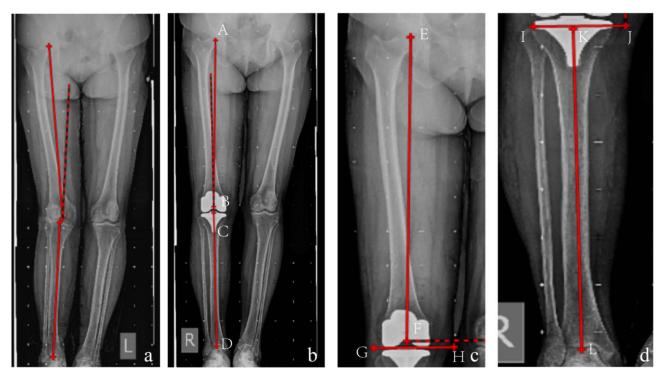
Postoperative measurement of component and limb alignment for RATKA. (a) Preoperative radiographs of limb alignment of patients. (b) Postoperative HKA angle: the angle between line AB and line CD. (c) Postoperative LDFA Angle: the angle between line EF and line GH. (d) Postoperative MPTA Angle: the angle between line IJ and line KL.
